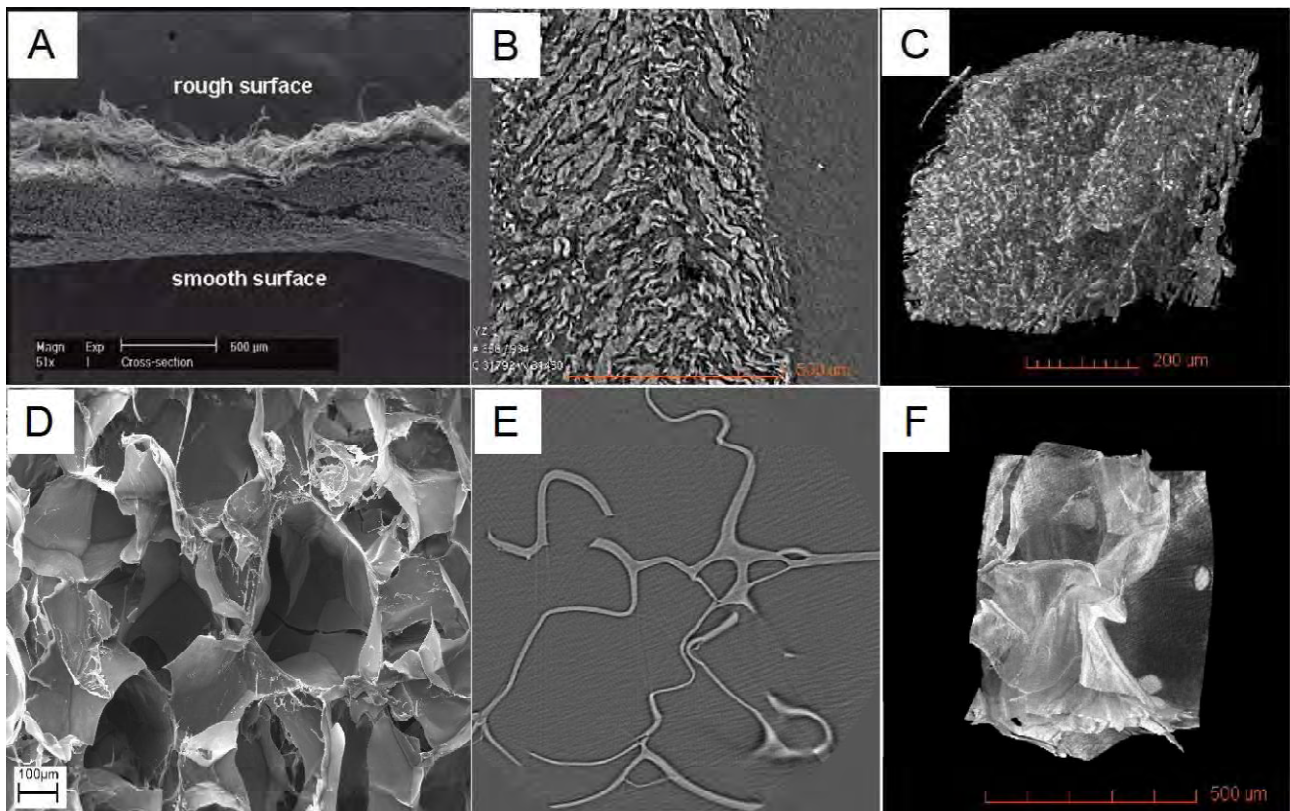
A) SEM image (147) of collagen membrane, B) 2D CT slice and C) 3D rendered volume D) SEM image (100x) of GPMTS cross-linked gelatin scaffold E) 2D CT slice and F) 3D rendered volume.
